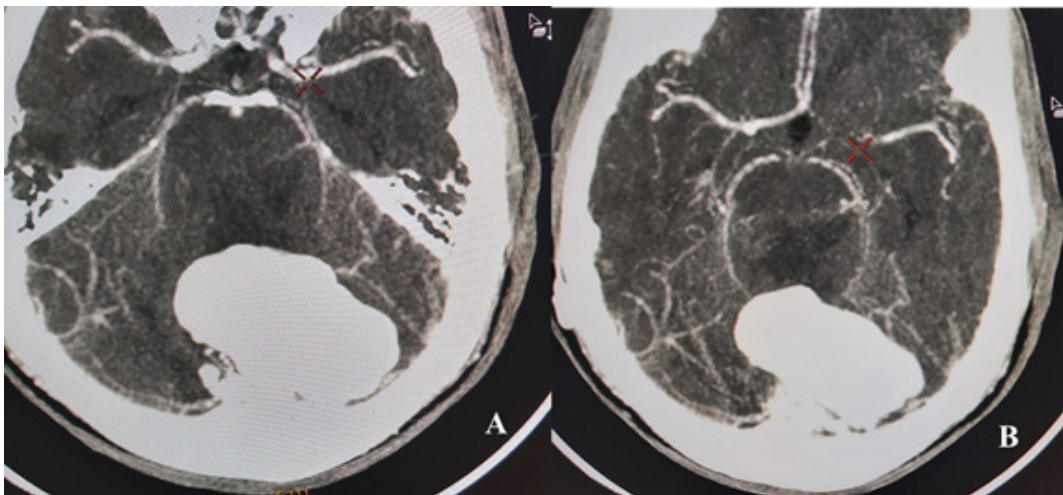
(A and B): Brain CT angiography with axial reconstruction revealed an aneurysmal dilation of the vein of Galen with numerous peripheral derivations.
